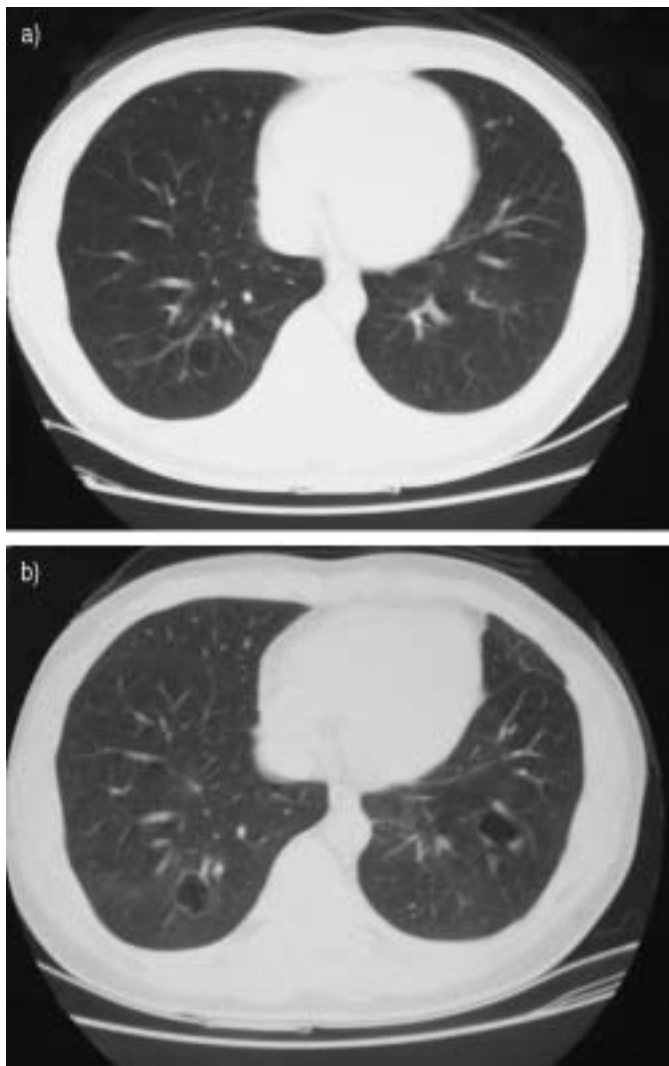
Computed tomography scan of the patient showing: a) an emerging thin-walled cystic lesion in the right lower lobe; and b) a slight increase in size of the original right lesion and a new development in the contralateral side at 2-yr follow-up.
